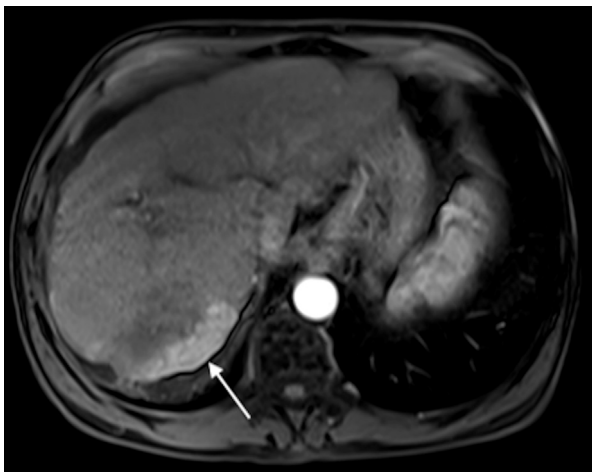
Subtracted axial postcontrast magnetic resonance imaging 1 month after conventional transarterial chemoembolization in a patient with multifocal hepatocellular carcinoma demonstrates residual enhancement in a treated segment 7 mass posteriorly (white arrow) measuring 6.9 cm.
